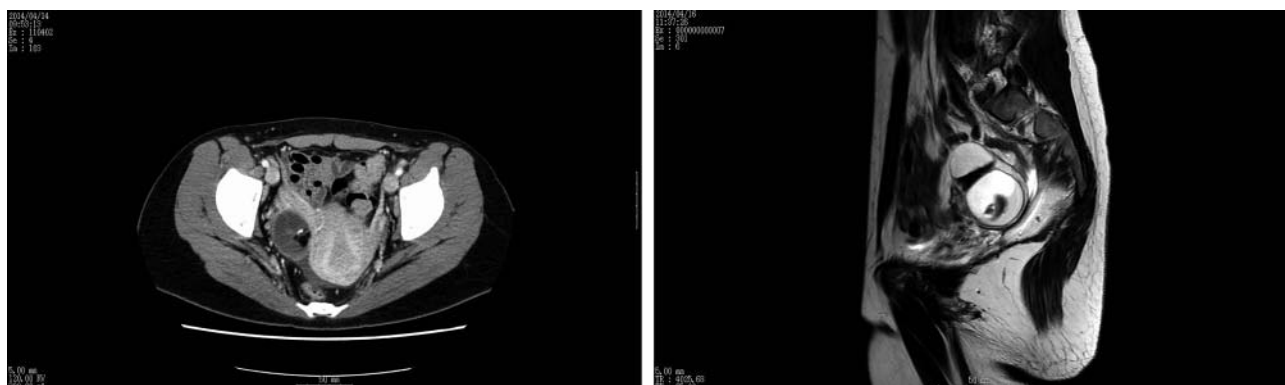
Left: The image of computed tomography (CT) examination of the abdomen, which demonstrates a right cystic adnexal mass with an internal focus of fat and high-attenuation material. Right: The image of magnetic resonance imaging (MRI) examination of the pelvis, which demonstrates a right cystic adnexal mass with an internal focus of fat and calcification
